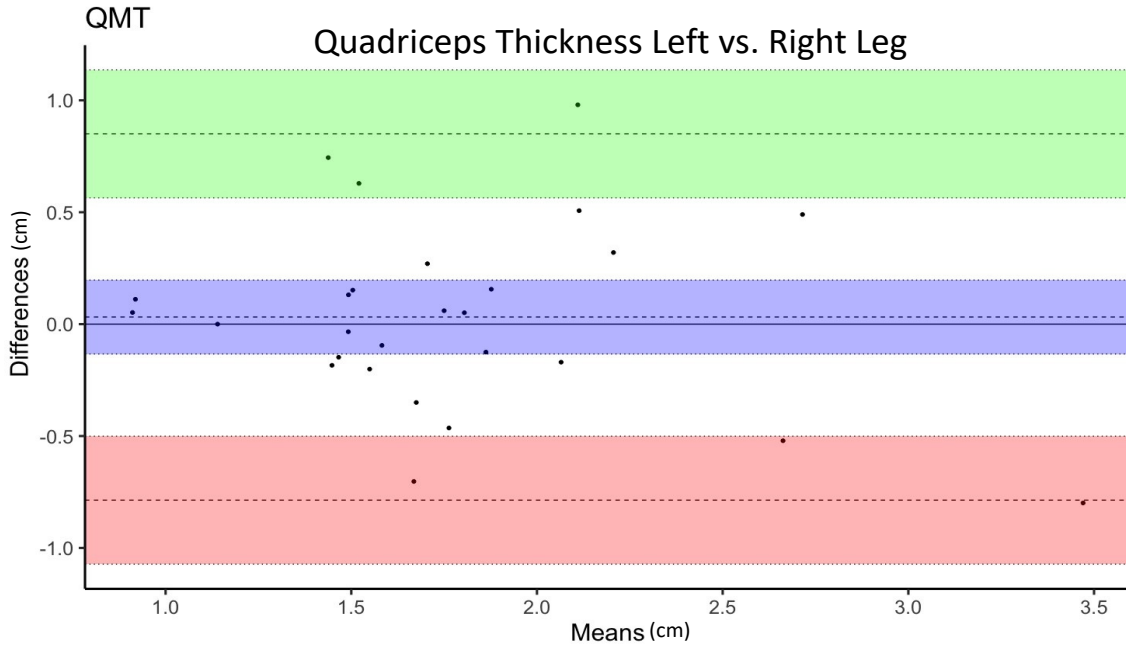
Bland-Altman plot analysis of quadriceps muscle thickness (QMT) values. The mean of the left and right measurement value for each patient with bilateral assessment was plotted against the absolute measurement difference between left and right values in cm. The green and red bars represent the confidence intervals two standard deviations above and below the mean difference between the left and right leg. Only patients with the measurement site of 3/5 distance from the anterior superior iliac spine (ASIS) to the upper border of the patella had bilateral ultrasound assessment, and were thus included in Bland-Altman analysis.
